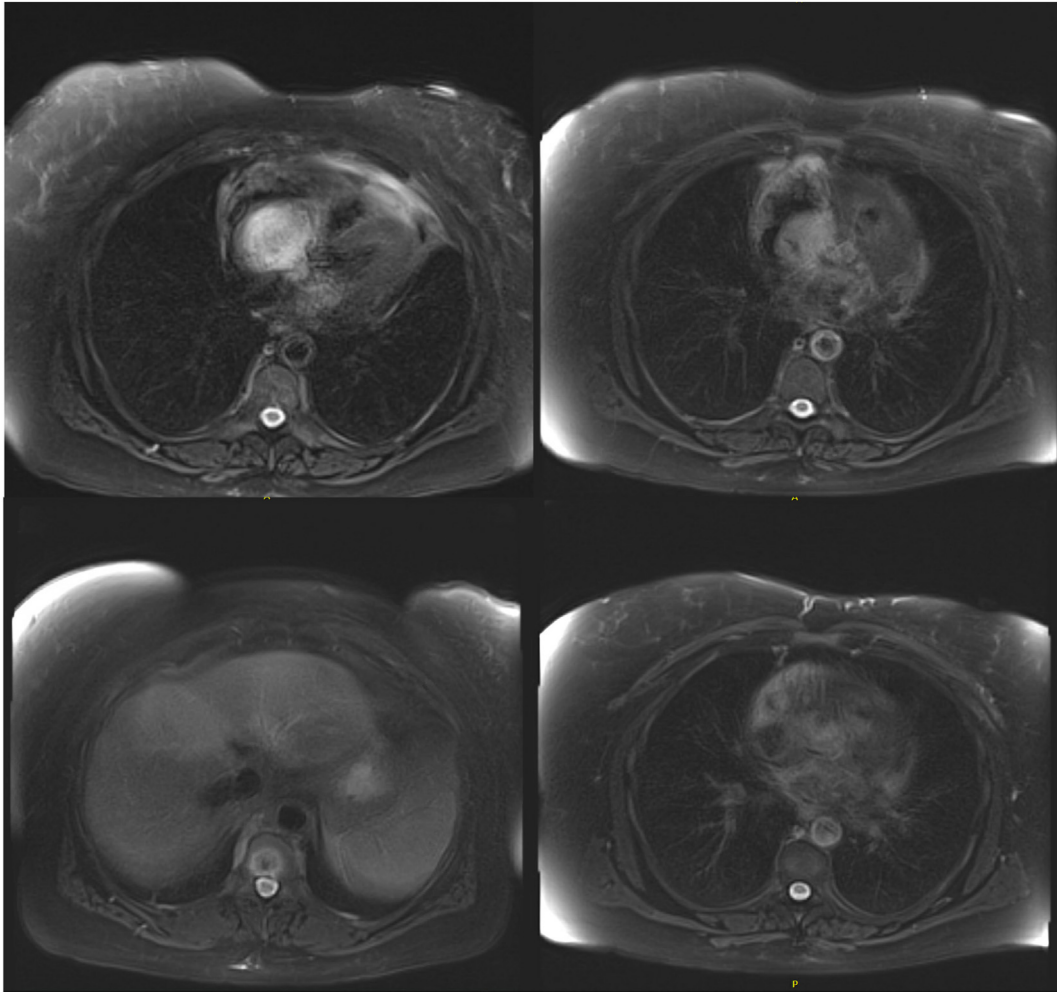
Cardiovascular magnetic resonance, three-plane T2-weighted images. The tumor is bright, suggesting high water content, and demonstrates some extension into the lower superior vena cava, without extension into the inferior vena cava, left atrium, or pulmonary vein. 3C, Three-chamber; 4C, four-chamber; SA, sagittal.
